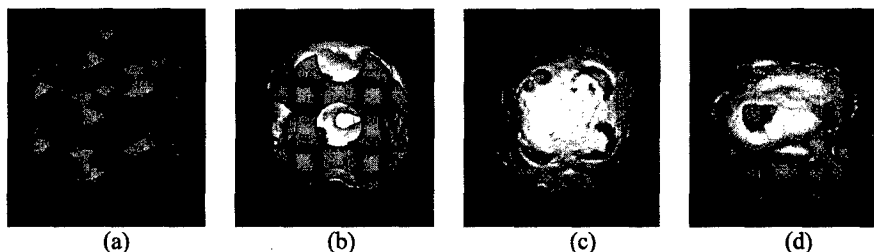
(a) Isometric view the STL design file for the subcutaneous-size scaffold, (b) bottom view, (c) top view, (d) side view of μ CT bone surface rendering data combined with the STL design file. PCL scaffold is shown in blue and bone is shown in white.
